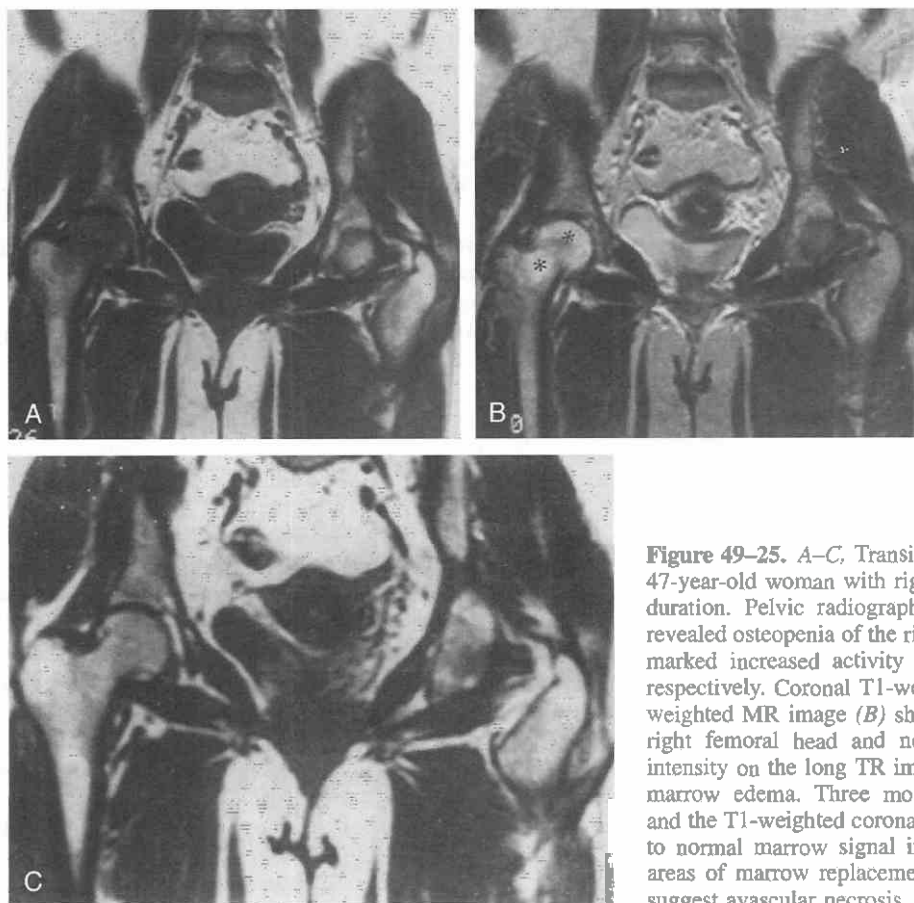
A–C, Transient osteoporosis of the hip in a 47-year-old woman with right hip pain of several months' duration. Pelvic radiograph and bone scan (not shown) revealed osteopenia of the right proximal femur and diffuse marked increased activity about the right femoral head, respectively. Coronal T1-weighted MR image (A) and T2-weighted MR image (B) show marrow replacement in the right femoral head and neck that becomes high signal intensity on the long TR image (asterisks), consistent with marrow edema. Three months later, symptoms resolved and the T1-weighted coronal MR image (C) shows a return to normal marrow signal intensity. No focal subchondral areas of marrow replacement were seen on any image to suggest avascular necrosis.
